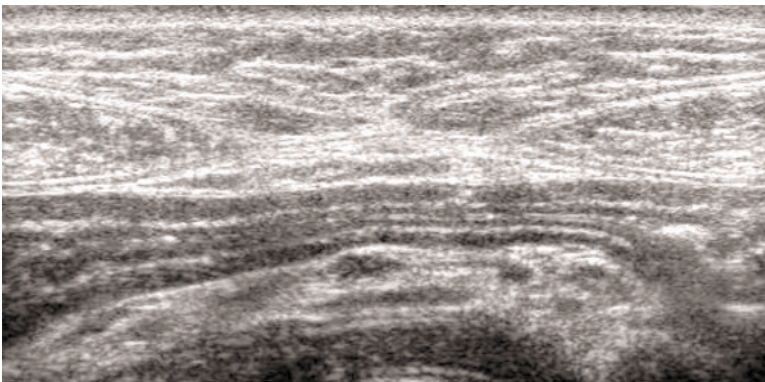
Mural stratification of the bowel wall: ultrasound anatomy
